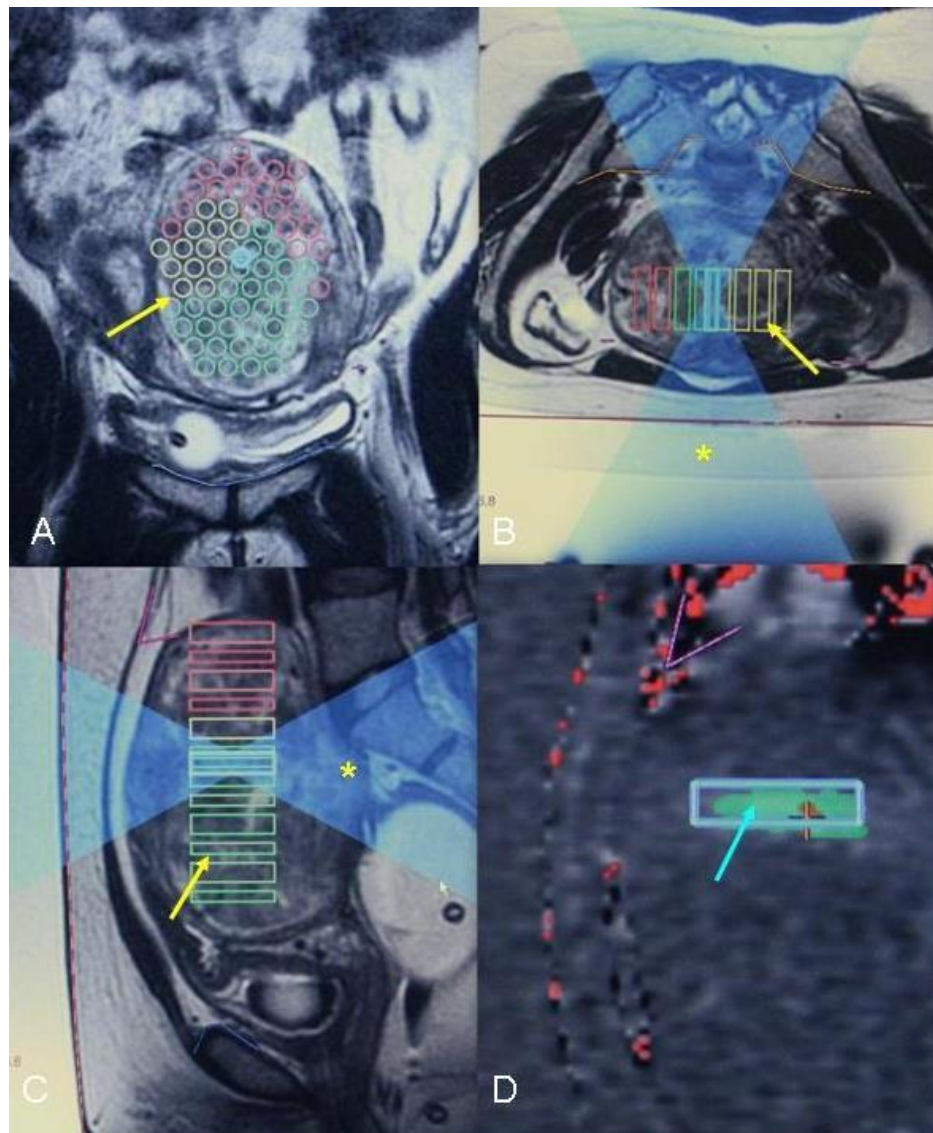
(left): 44 year old nulliparous woman with intramural fibroid and acute retention of urine. Coronal (A), axial (B) and sagittal (C) T2WI images obtained during treatment showing sonication spots (yellow arrow) and ultrasound beam path(*)
